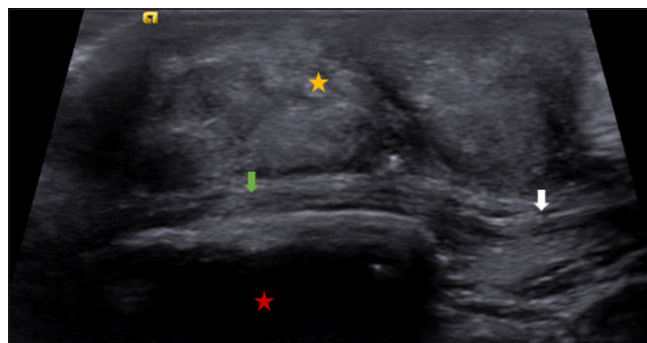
(a) Clinical photograph of the right knee showing a large nodular swelling along the anterior aspect. (b) Lateral plain radiograph of the right knee showing soft-tissue density swelling in the prepatellar region with normal underlying patella and distinct fat planes along the quadriceps and patellar tendons.
